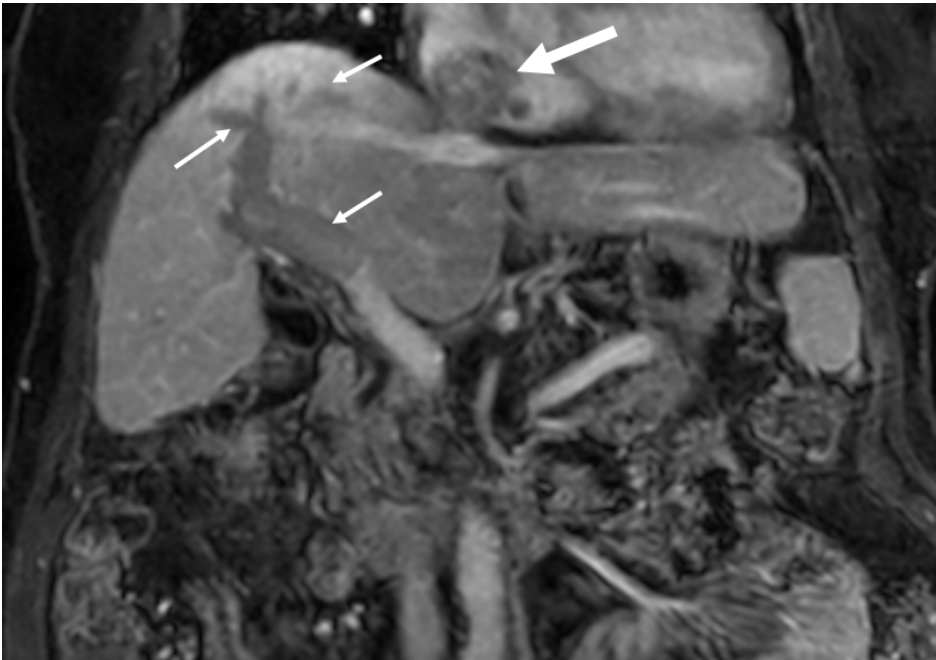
Coronal T1 post contrast MRI image, venous phase: multifocal HCC in the liver dome with a large, enhancing, expansile tumor thrombus in the right and main portal veins (small arrows) and in the right cardiac atrium (large arrow).
